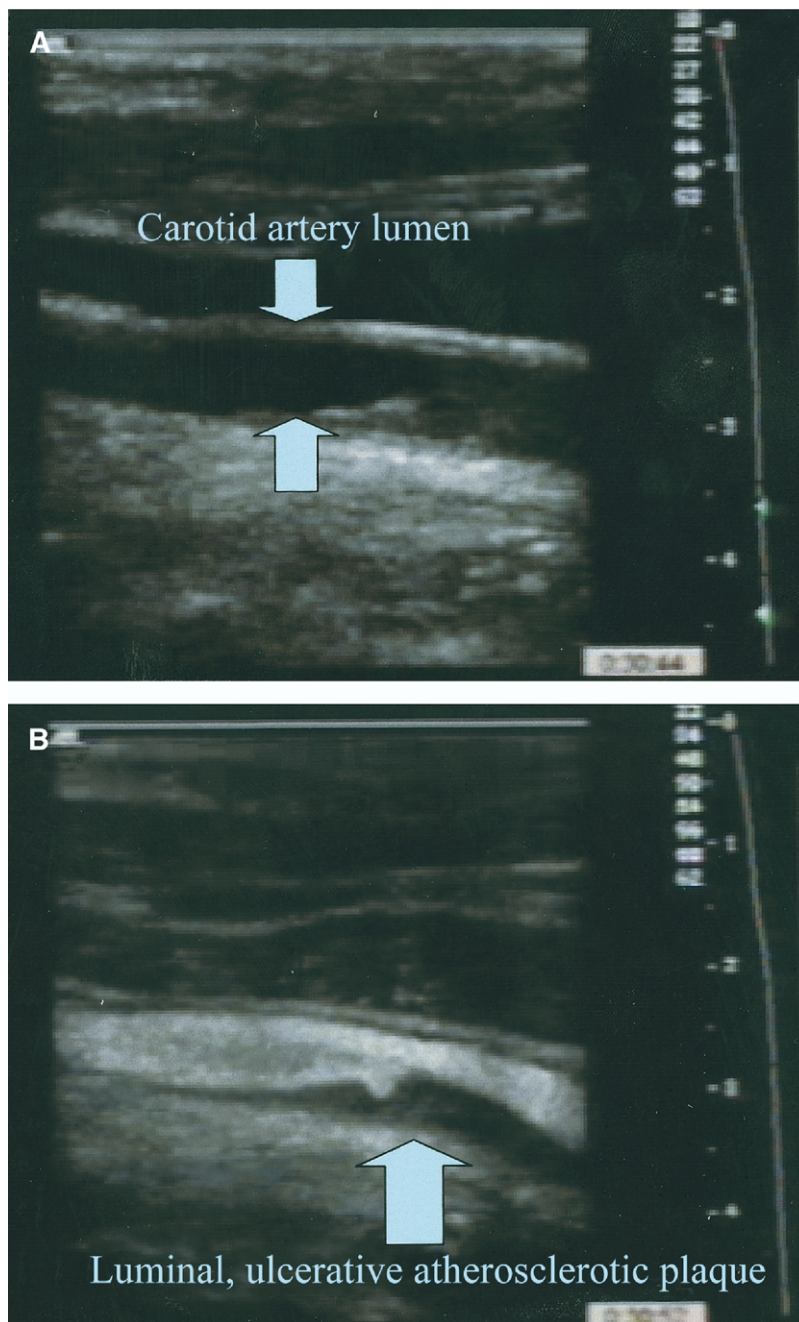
(A) This image is an example of an unenhanced carotid artery ultrasound image. (B) After an intravenous injection of an ultrasound contrast agent, the carotid artery lumen appears echodense (white) revealing an ulcerative plaque along the far wall. The presence of the ulcer was not clearly defined in the previous unenhanced ultrasound examination.
